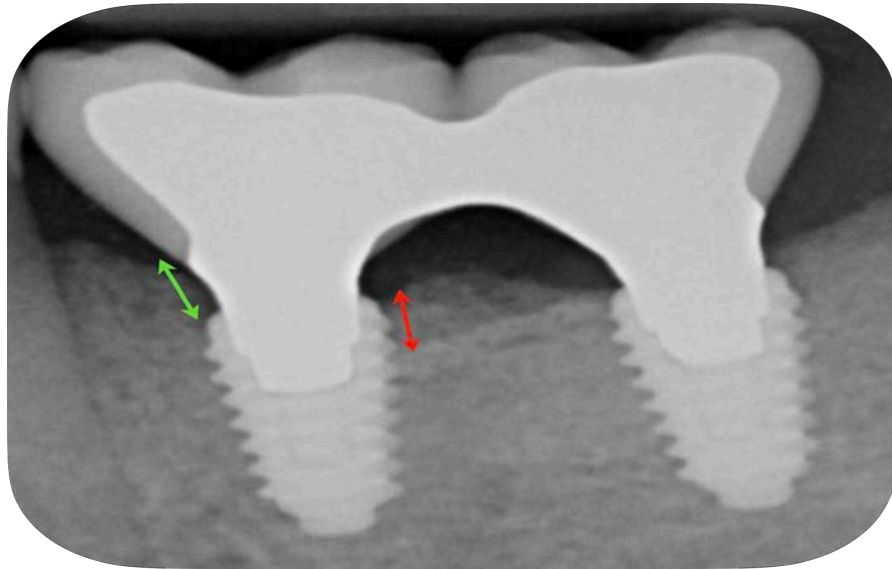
A radiographic view highlights the bone remodeling area (Green) and bone loss area (Red).
